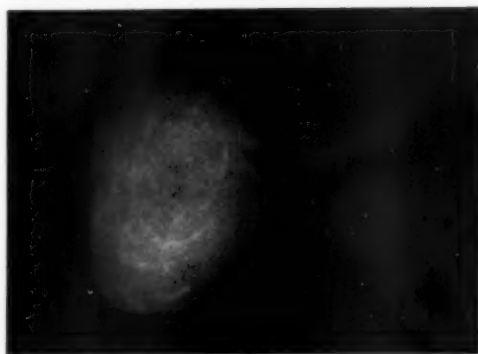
Roentgenogram of large calculus removed from the duodenal cap at operation. A fair amount of calcification is evident.
